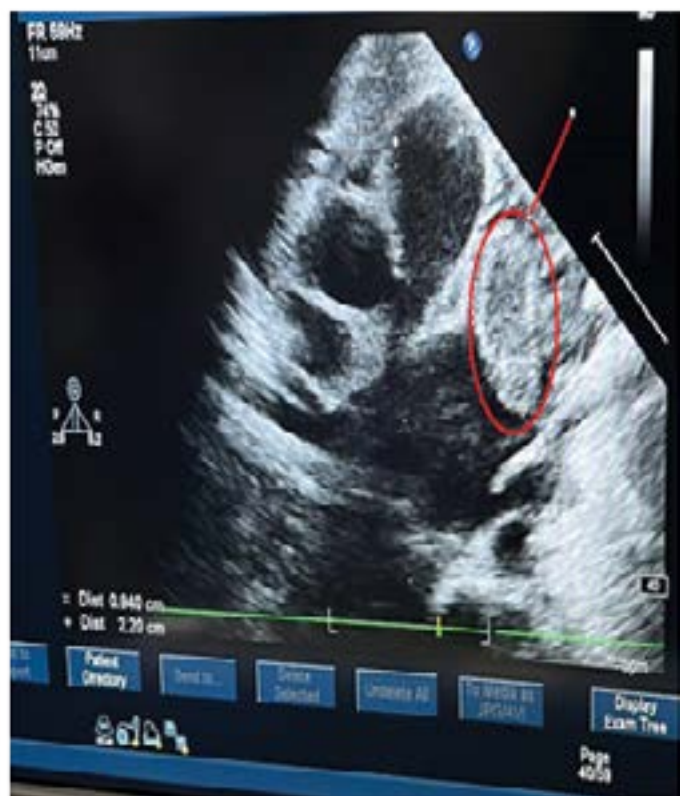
Echocardiograms showing the dilated left atrium and large (20 x 9 mm) thrombus-like mass in the left atrium, attached to the left atrial appendage (red cycles).
